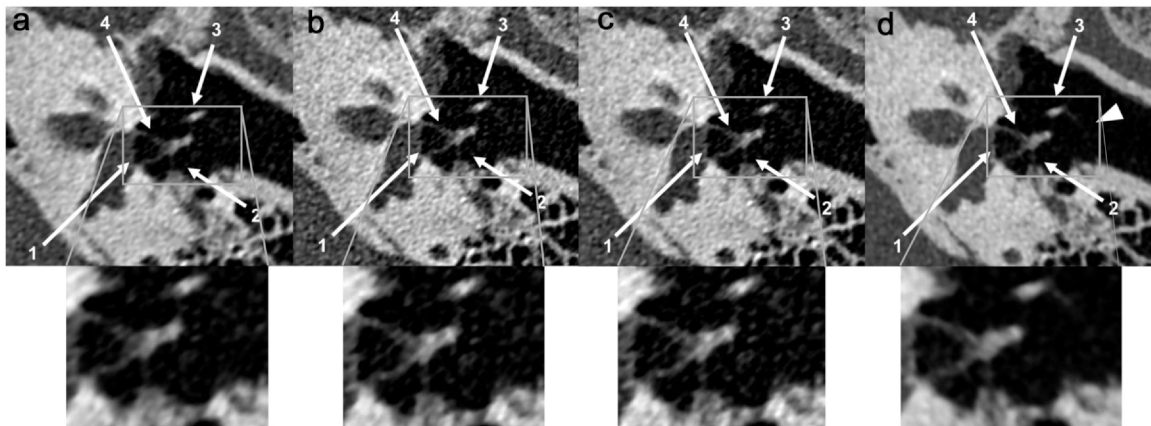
UHR-CT volume scan. Oval window (arrow 1). Pyramidal eminence and tendon of the stapedius muscle (arrow 2). Handle of the malleus (arrow 3). Stapes with anterior and posterior crus (arrow 4). Tympanic membrane (arrowhead). (a) HIR NR (AIDR 3D, 512² matrix). (b) HIR UHR 1024 (AIDR 3D, 1024² matrix). (c) HIR UHR 2048 (AIDR 3D, 2048² matrix). (d) DLR UHR 1024 (AiCE, 1024² matrix).
